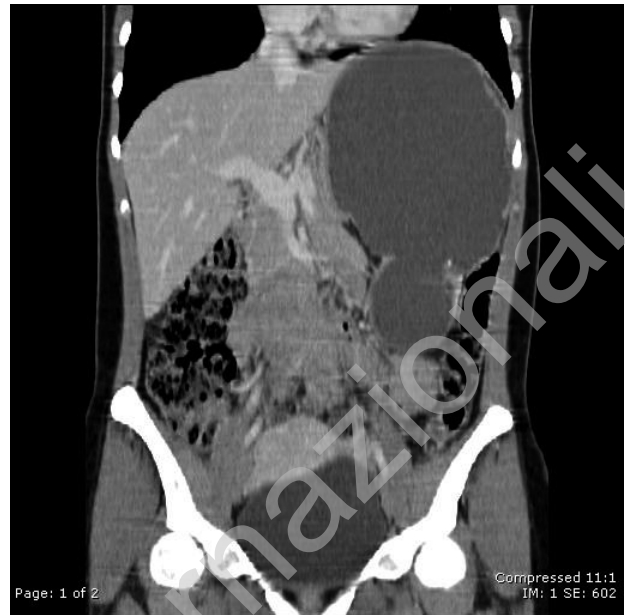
Coronal abdominal CT image showing the giant epidermoid cyst of the spleen.
